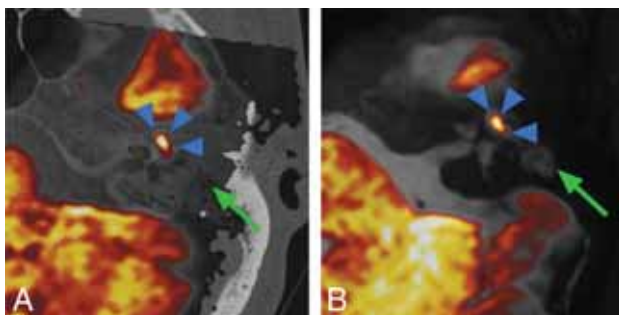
Left middle ear mastoid region. A, CT-DWI fusion image of a cholesteatoma in red (blue arrowhead) and inflammatory tissue in gray (green arrow). B, T2WI-DWI fusion image of cholesteatoma in red (blue arrowhead) and inflammatory tissue in gray (green arrow).
